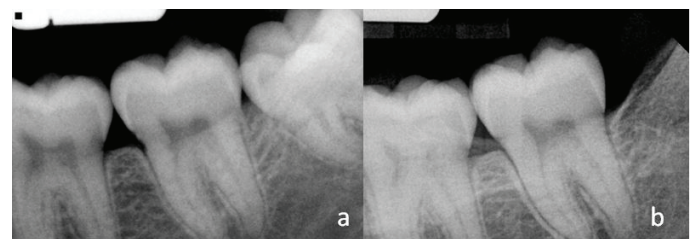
Vertical IMP; a) Pre-operative radiograph; b) Post operative radiograph showing improved ABH at re-assessment period.
